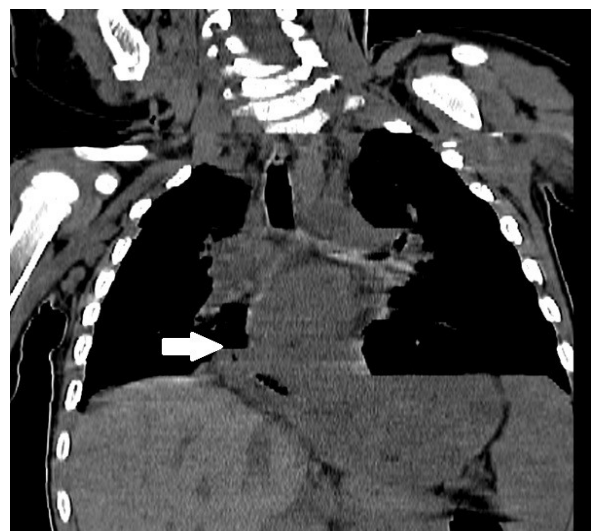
Coronal section reformatted thorax CT demonstrates the partial herniation of stomach into thorax
